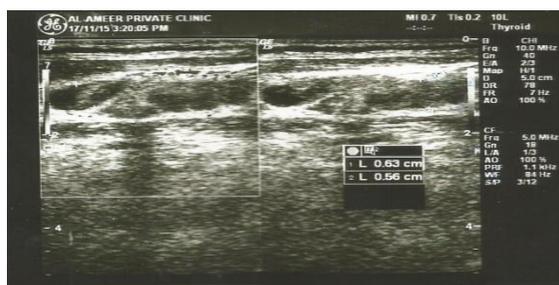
Grey scale ultrasonography of right posterior TLA after 45 days of anti TB treatment show decreasing in the size of the lymph nodes and preserving fatty hilum. (1st reading S=12.7mm & 2nd reading S= 5.6mm)
